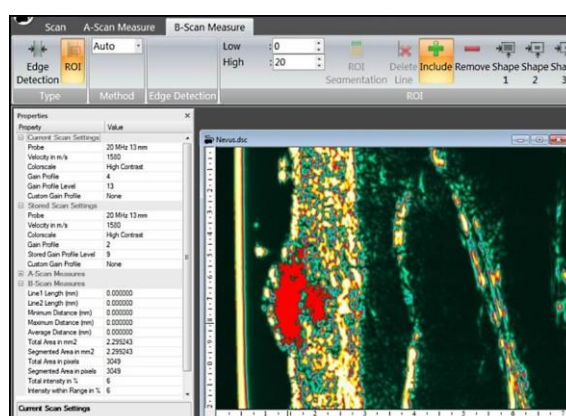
Example of measurement of a tumor cross-section using the Cortex DermaScan C device (not cNF). Source: <https://cortex.dk/scientific-ultrasound-dermascan-c/>
